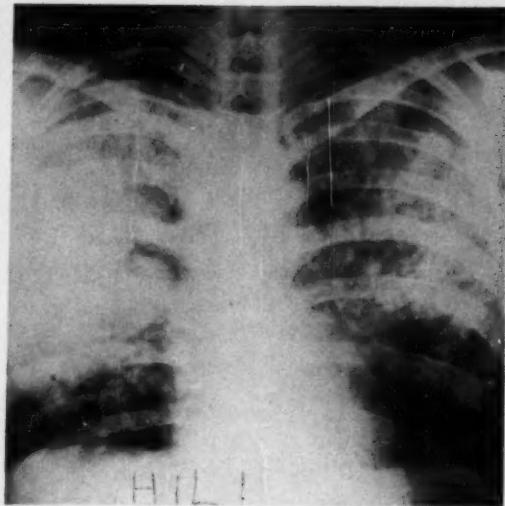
Case 16. Radiograph showing upper and mid-zone consolidation. The abnormal shadows had almost completely cleared eight months later.
